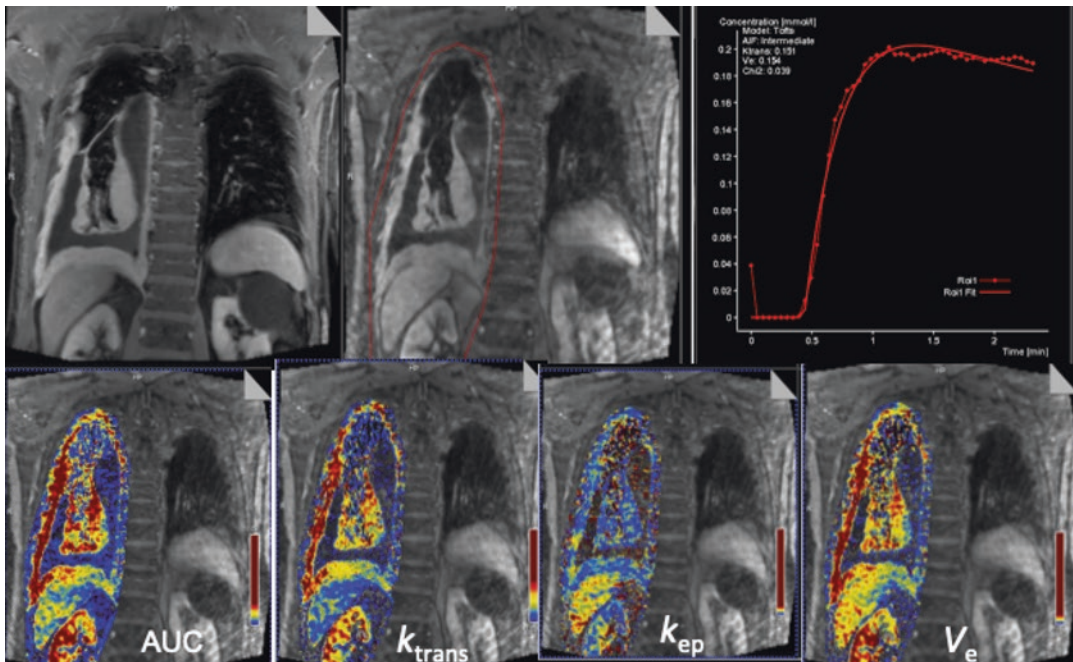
A 48-year-old man with right-sided epithelial mesothelioma who underwent MRI for surgical planning. Coronal post-contrast and multiparametric maps depicting perfusion parameters of the tumor. MR-determined pharmacokinetic parameters: AUC area under the curve and represents blood volume, k_{trans} transfer constant
